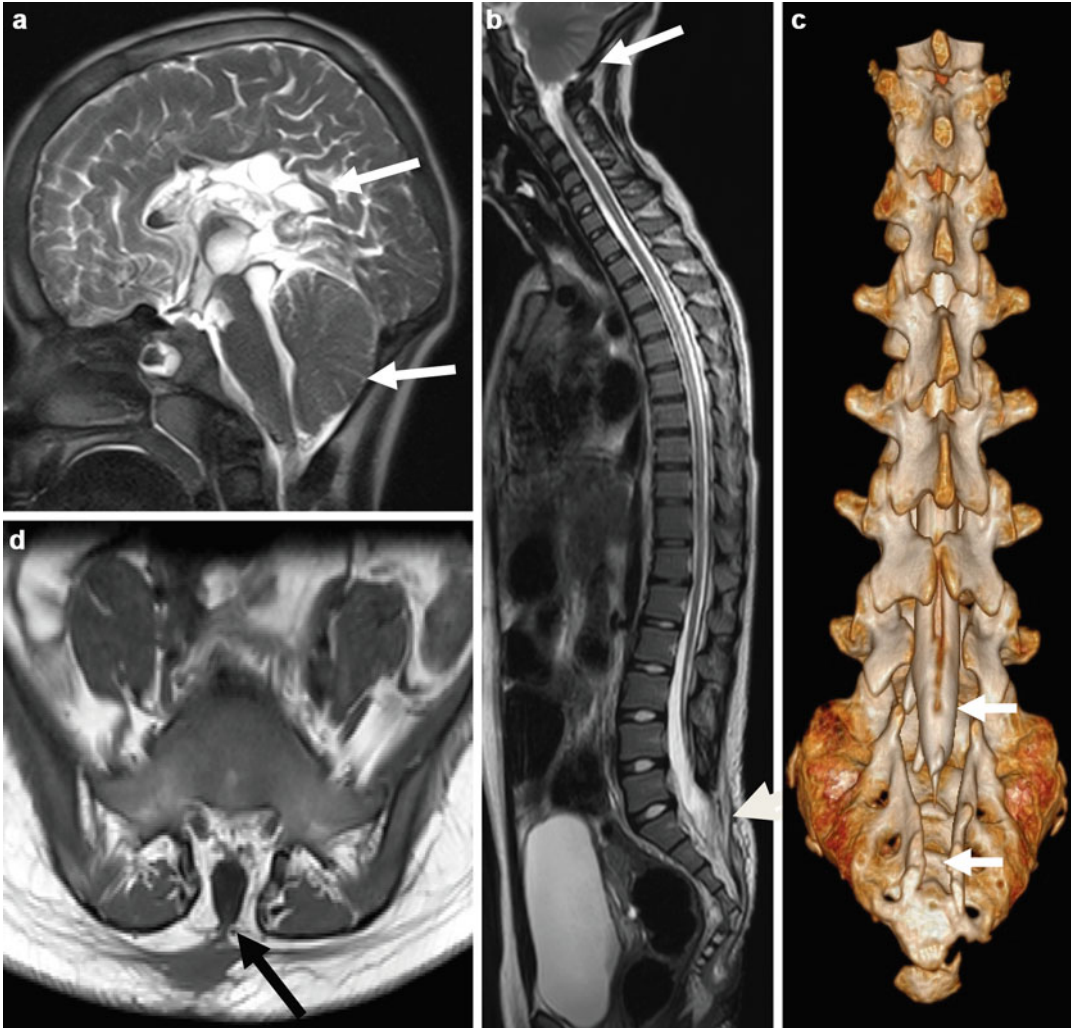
(a–d) An 11-year-old female with Chiari II malformation. MRI images of the brain showed cerebellar tonsil located below the foramen of magnum (a) (*lower arrow*) and (b) (*upper arrow*) with absent corpus callosum (a) (*upper arrow*) and mild ventriculomegaly. There is a
